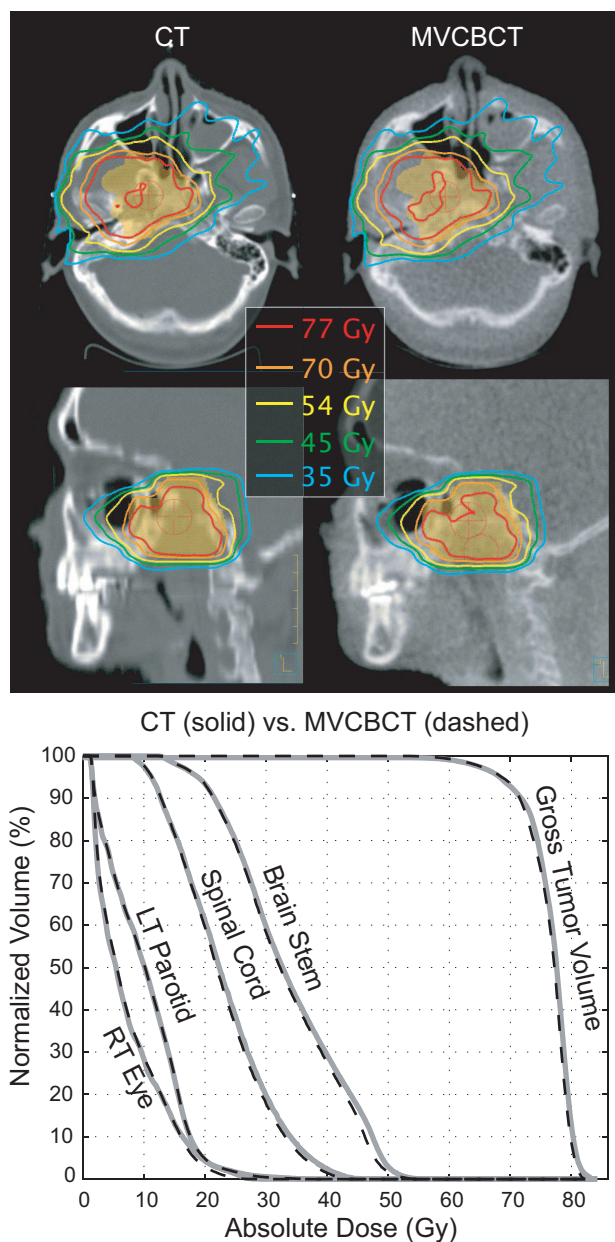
Dose calculation on a patient treated for a recurrent nasopharyngeal carcinoma with IMRT. No weight loss or anatomical deformation was observed between CT and MVCBCT images. Isodose lines at the treatment isocenter planes on the conventional CT and MVCBCT are presented (above). Good qualitative agreement is observed with DVHs (below) obtained from dose calculations performed using CT (solid lines) and MVCBCT (dashed lines).
